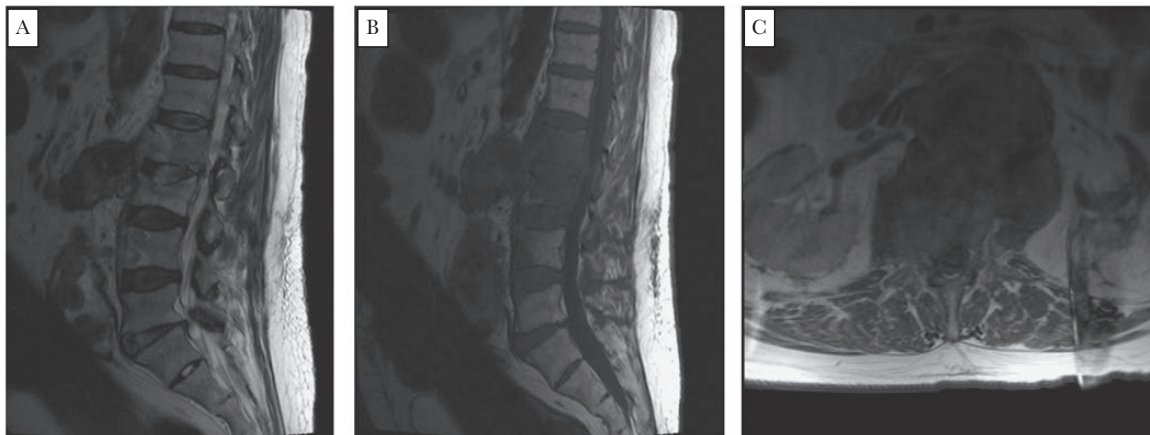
Lumbar spine MRI with psoas muscle and T10 to L3 epidural abscess, L1, L2, and L3 osteomyelitis. Images: (A) sagittal T2, (B) sagittal T1, and (C) axial.
